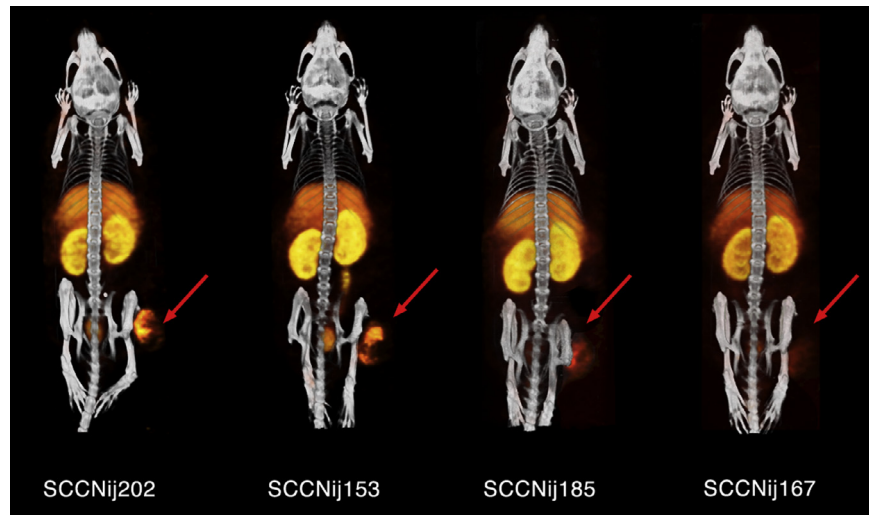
MicroSPECT images of ^{111}In -cetuximab-F(ab') $_2$ obtained at 24 h p.i. of SCCNij202, 153, 185 and 167. Arrow = s.c. tumor location in right hind leg.
